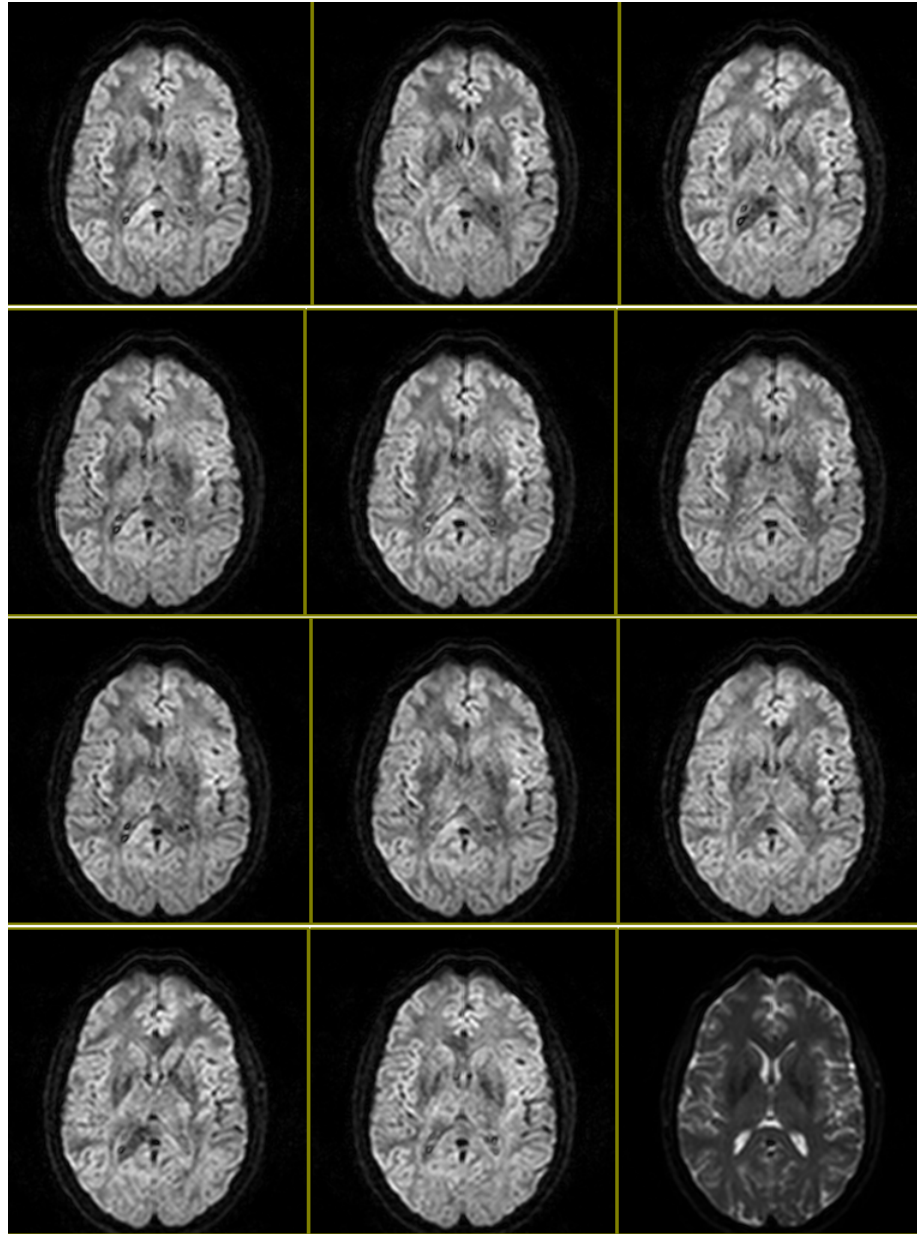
DWI for a human brain scan acquired using a Phillips Achieva 3.0 Tesla scanner with slices parallel to the anterior-commissure posterior-commissure line. The bottom right image corresponds to the image S_0 acquired with no diffusion sensitizing gradient.
